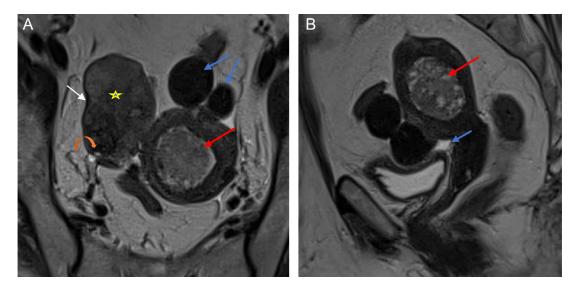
Fibrothecoma of the right ovary: Axial (A) and sagittal (B) T2-weighted MRI: lobulated solid mass with heterogeneous signal, T2 intermediate (yellow star) with a hypointense T2 pseudocapsule (white arrows) and small subcapsular cystic zone (curved arrow) associated with glandular-cystic endometrial hypertrophy (red arrow). Note: pedunculated uterine myomas and thin layer of pelvic effusion (blue arrow).
